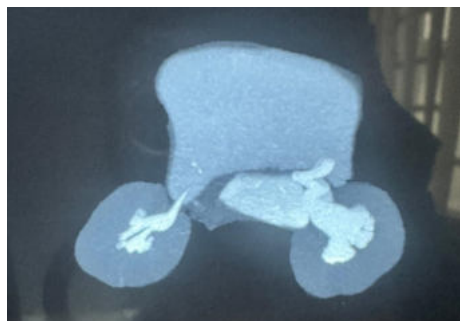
CT Urogram Showing Contrast In Vagina And Dilated Pcs And Proximal Ureter
